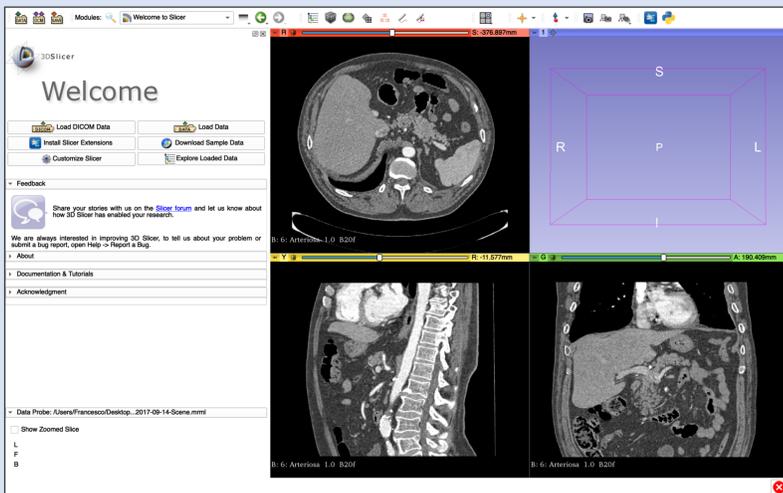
A CT/MRI dataset is imported in 3D Slicer.
